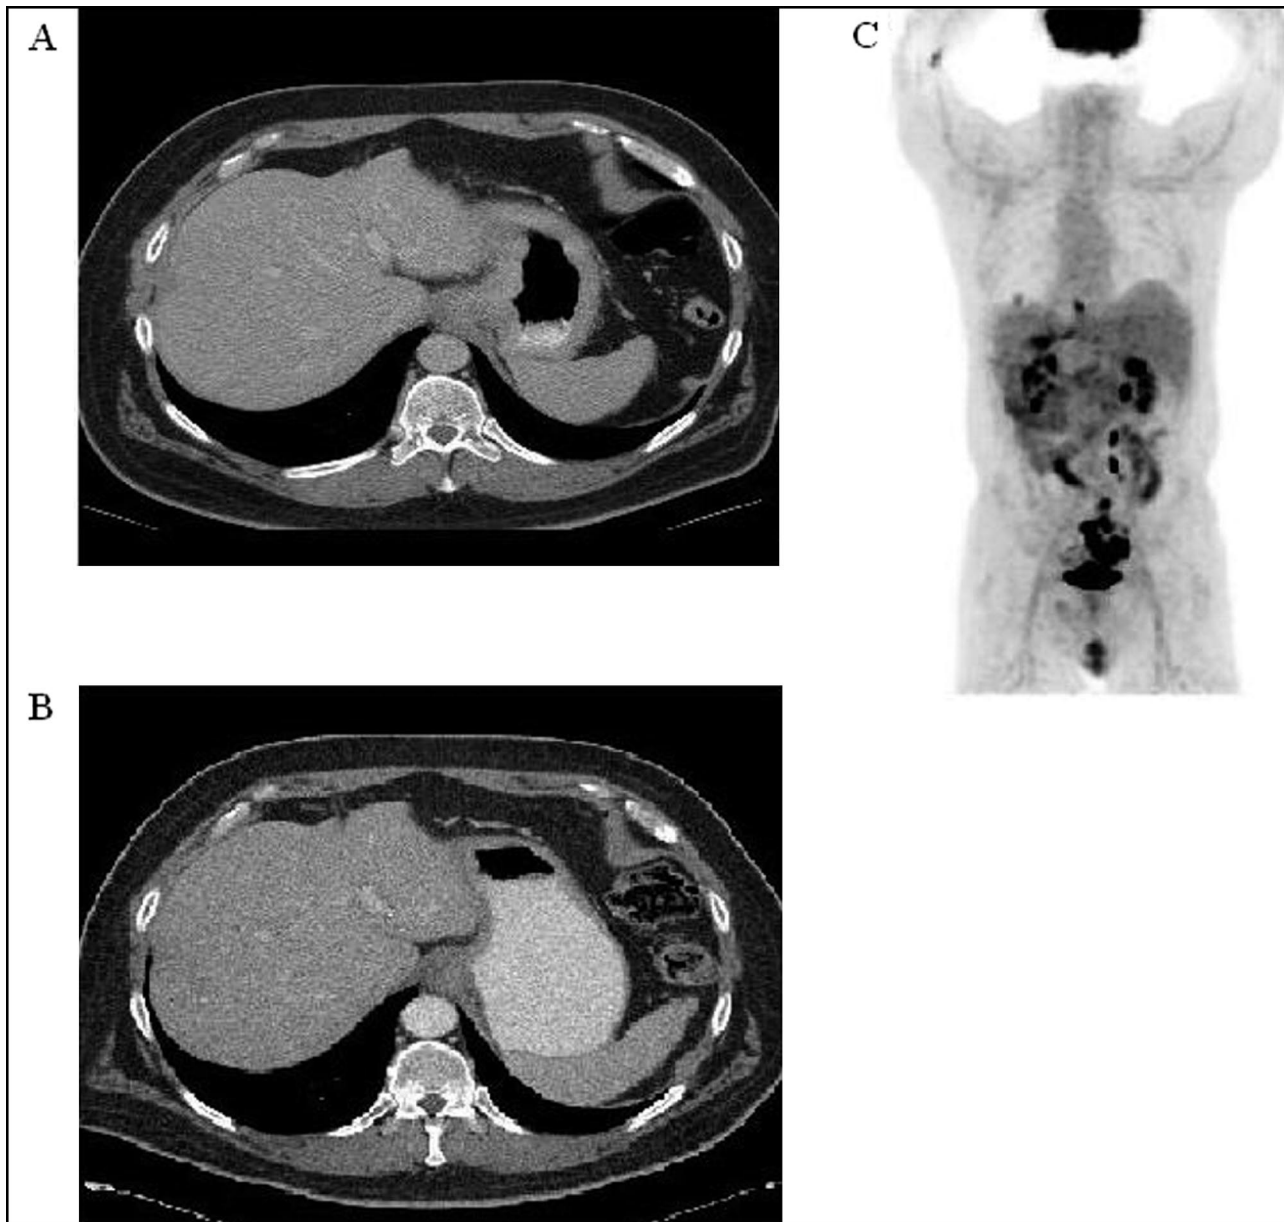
Imaging studies for case 1. (A) Pretreatment CT showed thickening of the GE junction with extensive gastric involvement (thickened gastric wall). (B) Postchemotherapy CT showed treatment response with decreased size of GE junction tumor and decreased thickening of the gastric wall. (C) Negative systemic disease demonstrated by PET at the time of CNS relapse.
